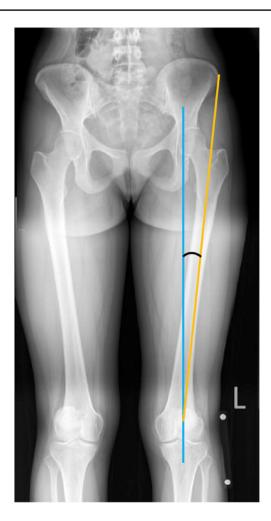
Q-Angle. AP radiograph measuring the angle between a line from the anterior superior iliac spine to the mid-patella and a vertical line connecting the center of the patella with the tibial tubercle. Normal values are between $14-16^{\circ}$ for men and $16-18^{\circ}$ for women
